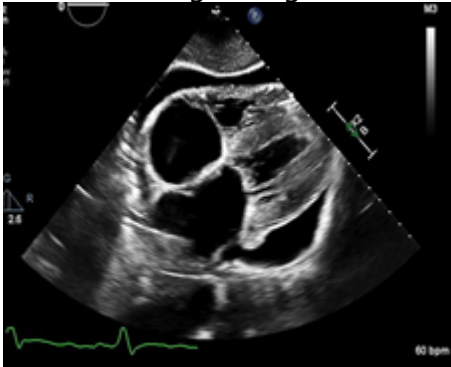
Parasternal short axis image of patient.
